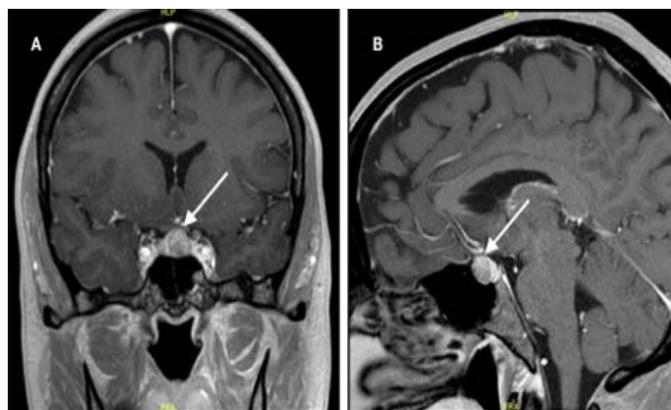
T1 weighted, post contrast coronal (A) and sagittal (B) MRI images of the sella turcica showing pituitary lesion (white arrows).
